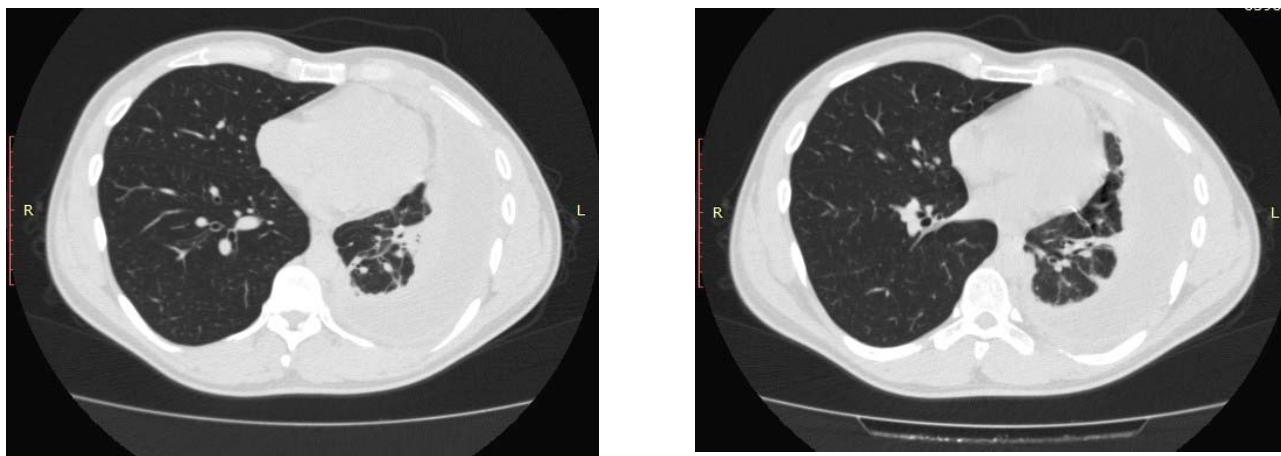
Chest CT on day three of treatment
